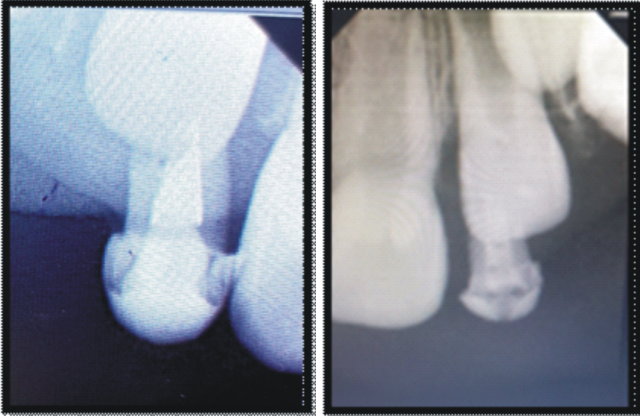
Intra Oral Peri apical radiograph of (a) 52 (b) 62
